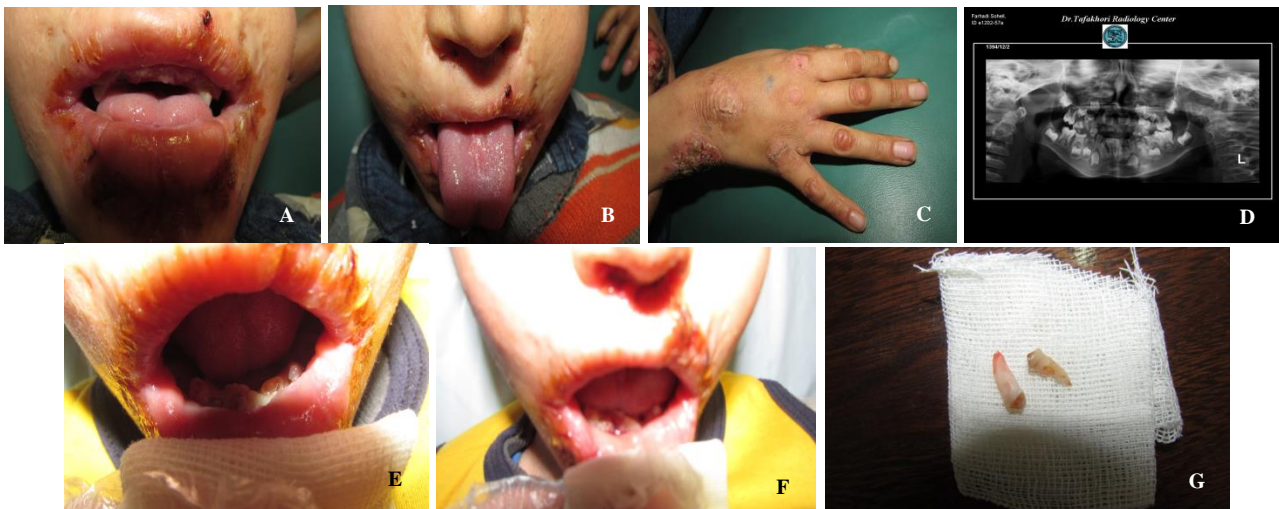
Crusted lesion around the mouth of 6-year-old patient (A), normal feature of tongue in the 6-year-old patient (B), erythematous scaly plaques on hands of the 6-year-old patient (psoriasis-like form) (C), panoramic radiography of the 6-year-old patient (D), over-retained primary incisors (71 and 81) (E), after extraction (5 minutes later) (F), extracted teeth (G)
